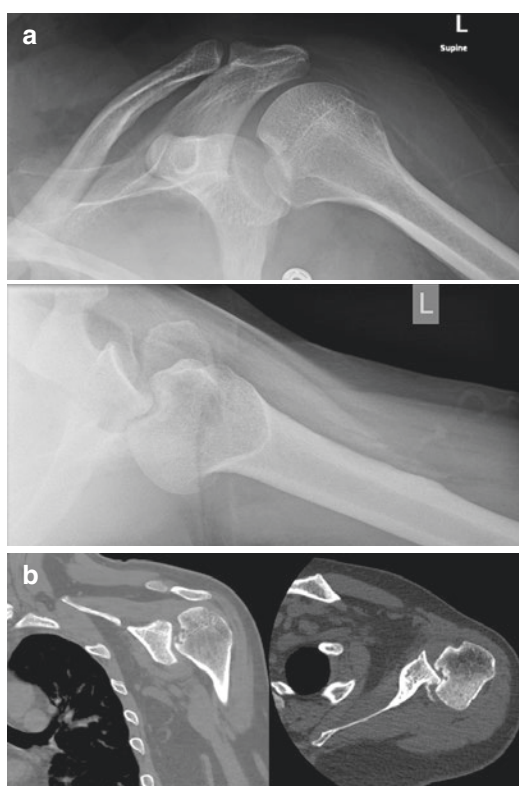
(a) Radiographs of a locked posterior shoulder dislocation in 37-year-old male patient AP (top) and axillary view (bottom). Reverse Hill-Sachs lesion can be seen on both views. (Courtesy Jarret Woodmass, MD). (b) CT scan of patient in (a) showing locked posterior shoulder dislocation, coronal view (left) and axial view (right). (Courtesy Jarret Woodmass, MD)
